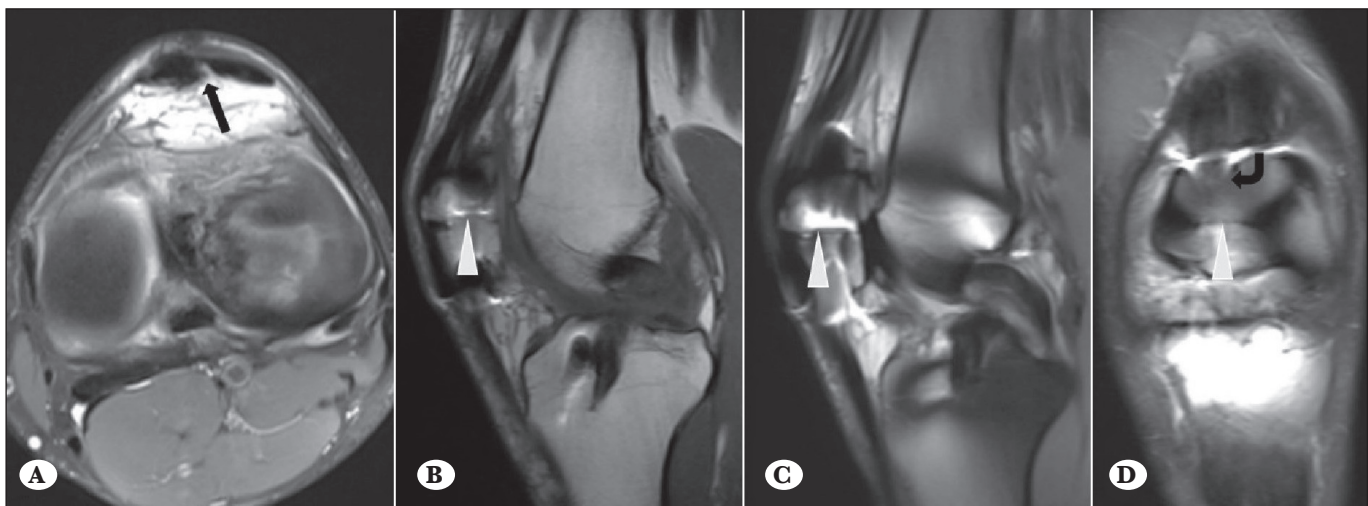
Axial PD-weighted fat suppressed MR image (A) showing patellar tendon defects (arrow) due to use of autogenous bone-patellar tendon-bone graft. Sagittal T1-weighted (B), sagittal PD-weighted fat suppressed (C), and coronal PD-weighted fat suppressed (D) MR image showing nondisplaced patellar bone fracture (white arrow head) and patellar cleft (curved arrow).
